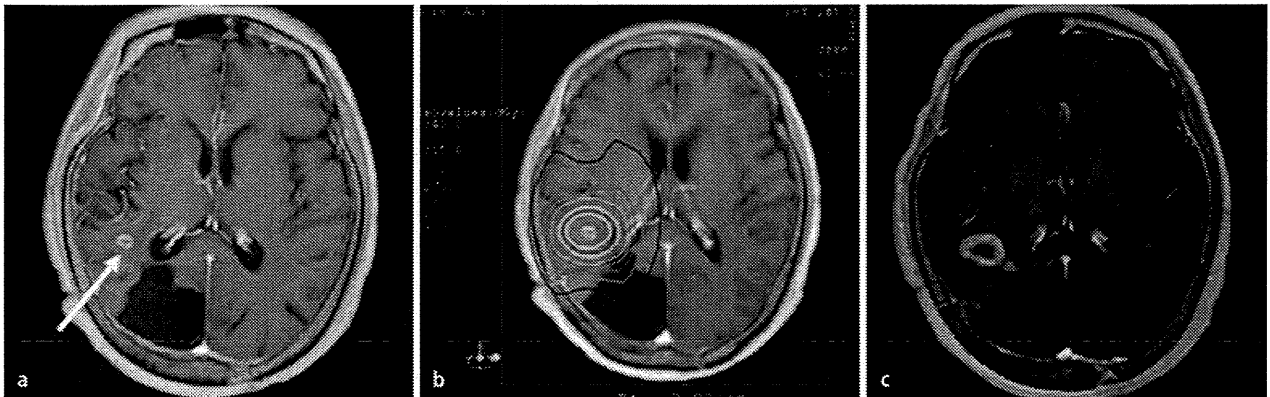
▲ Imaging for a patient treated with reirradiation with SRT. a Postcontrast T1-weighted MRI before reirradiation. b Isodose curves for SRT representing 100-10% of the prescribed dose at 10% intervals. c Postcontrast T1-weighted MRI at 5 months after reirradiation
